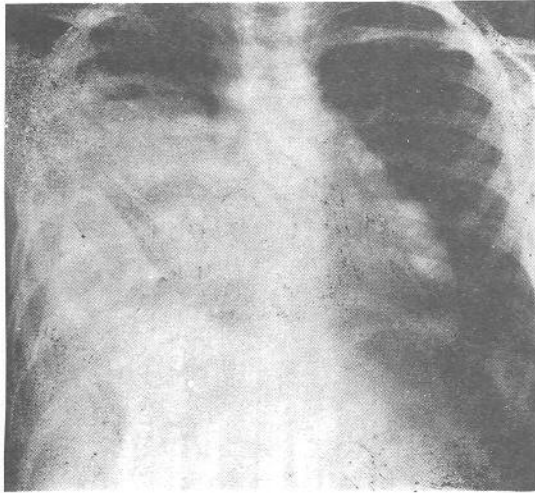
Chest radiograph on admission shows complete opacification of the lower two-thirds of the right hemithorax by a large right middle lobe fluid collection containing an air-fluid level, with a right pleural effusion, and upward bowing of the minor fissure by the mass.
